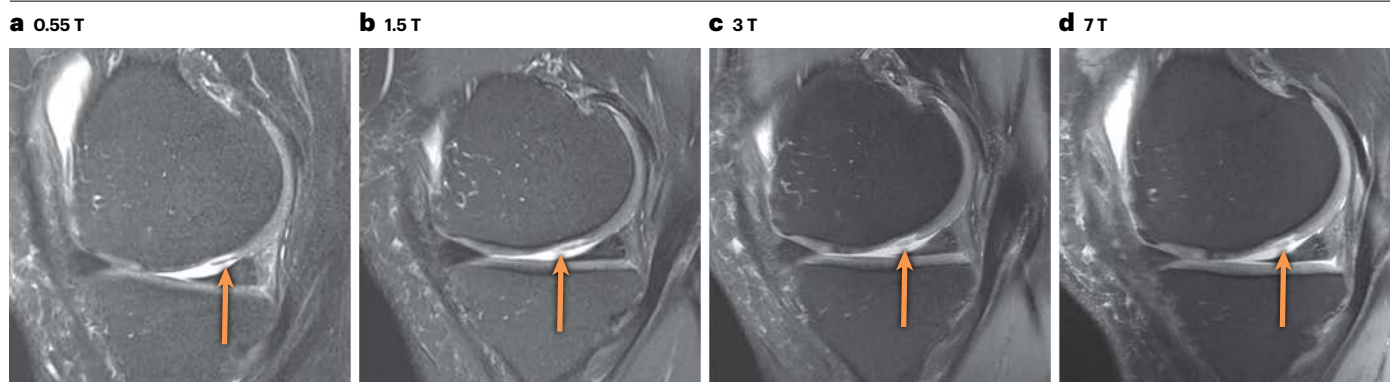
Direct comparison of different magnetic field strengths for cartilage surface damage evaluation. All images are intermediate-weighted fat-suppressed and acquired in the sagittal plane. The medial tibiofemoral compartment of the knee joint is shown with orange arrows indicating a delaminating surface lesion. a, 0.55 T; b, 1.5 T; c, 3 T; and d, 7 T MRI. All images were acquired with similar
